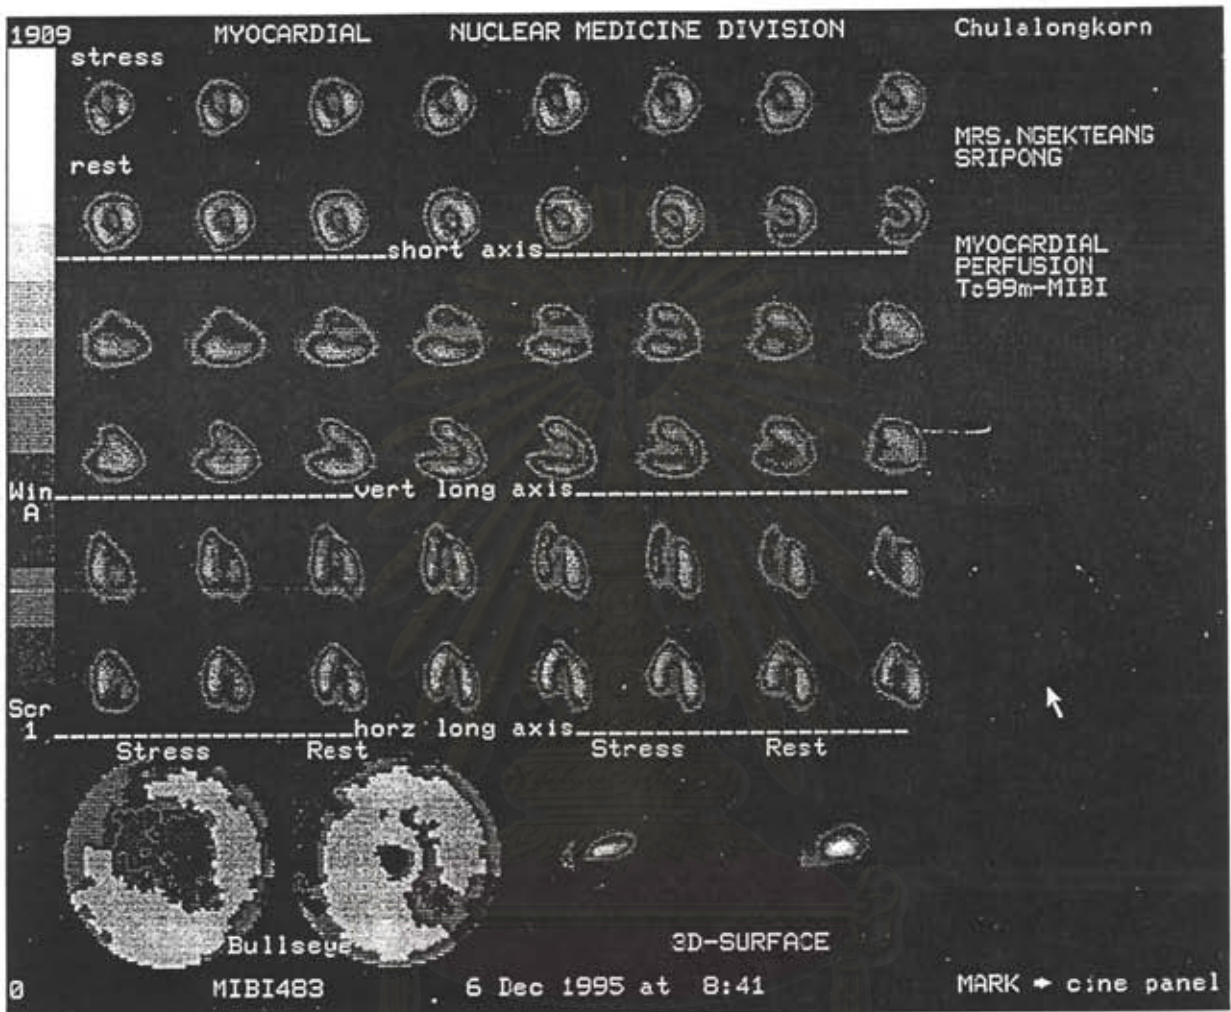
Tc-99m Sestamibi SPECT images before PTCA from a 65 year female patient with a reversible filling defect (myocardial ischemia) at anteroseptal and apical wall corresponding to a significant LAD coronary artery stenosis
